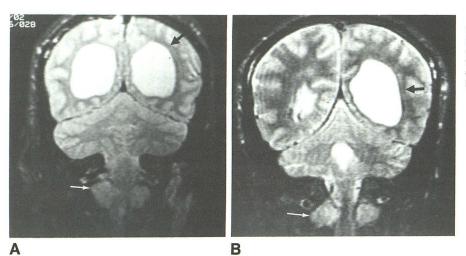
A and B, Coronal T2-weighted MR images of twin 1 (A) and twin 2 (B). Note poorly formed deep white matter (black arrow) around colpocephalic lateral ventricle (twin 2 has had ventriculostomy in right lateral ventricle). Identical kissing neurofibromas wrap around cord just below foramen magnum (white arrow).
